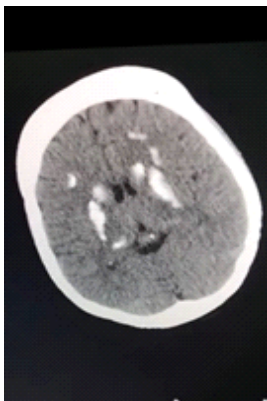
Computed tomography of the brain demonstrated multiple symmetrical calcifications involving bilateral basal ganglia and thalami
